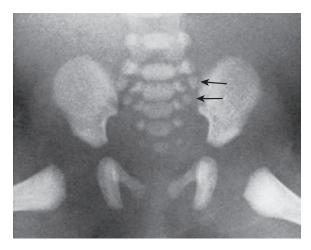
Anteroposterior radiograph of a 34-week fetal pelvis showing two of the eventual three ossific centers (arrows) of the costal contributions to the alae. These form in the cartilage that anchors the fetal sacrum to the auricular processes of the iliac wings.
